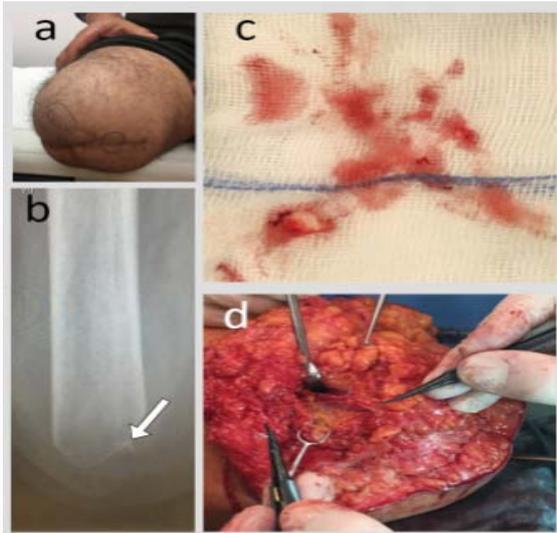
Patient 5 TF Amputee, NRS 7. The algorithm revealed a positive HT-sign ventrally and a bony fragment medially (a), X-ray confirmed the bone fragment (arrow) (b). Fragment was removed (c) and the neuroma transferred to deep recipient nerve (forceps, right) (d) reducing pain level to NRS 1.5.
